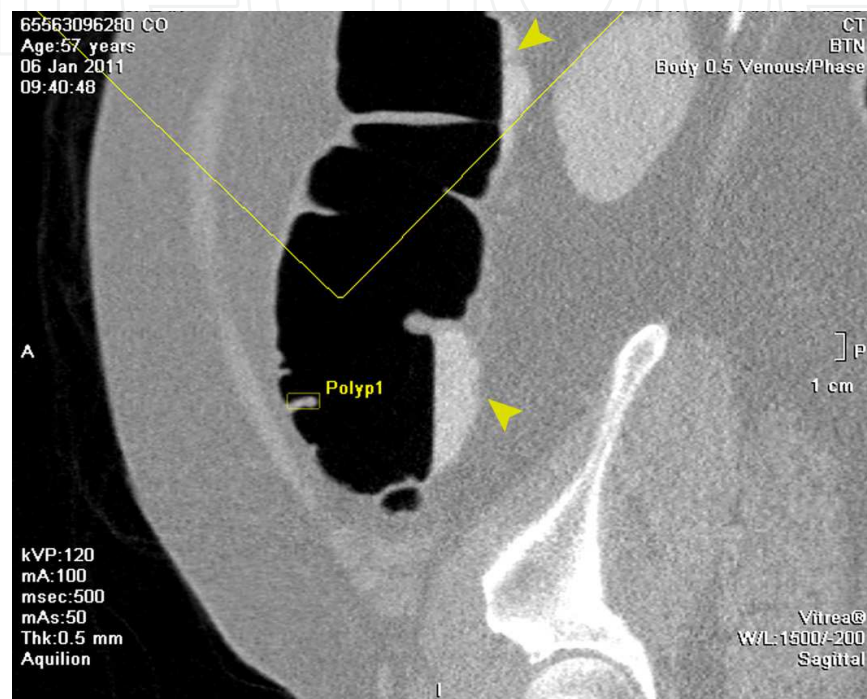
Fecal tagging with orally ingested barium: 2D sagittal CT colonographic image shows high attenuation of contrast marked fecal residuals and residual fluid (arrowheads), as well as a polyp in the ascending colon.
